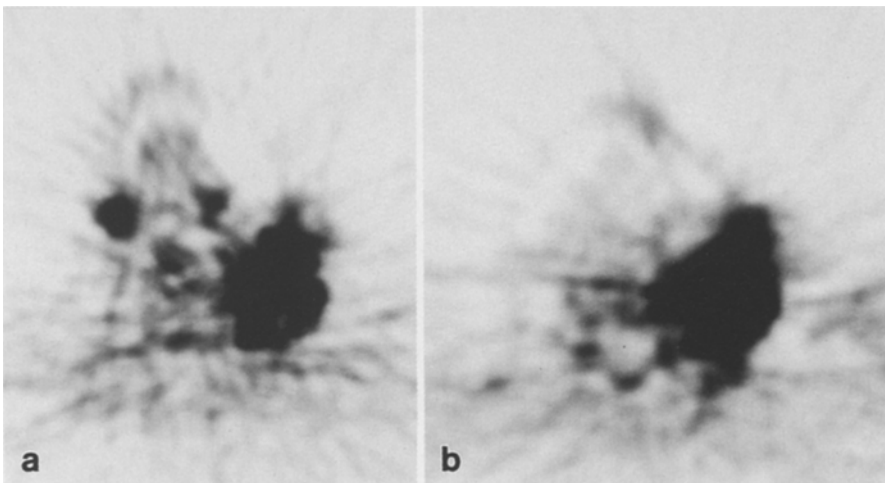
a PET imaging of case 1 showing the low and diffuse distribution of L-[^{11}C]-methionine within tumor. The submandibular glands are also well visualized b PET imaging of case 1 with FDG shows a low and diffuse uptake of tracer in tumor
